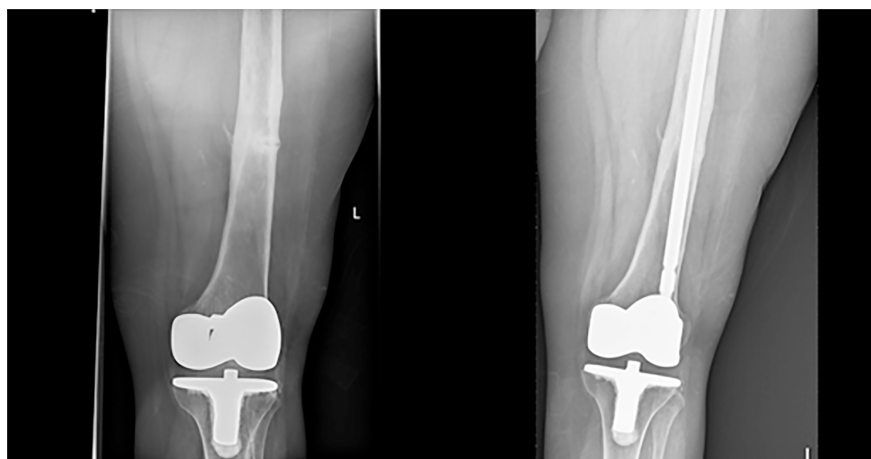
Plain radiographs of the “dreaded lucent line” and distal unlocked intramedullary stabilisation to minimise the stress riser around a knee replacement.
